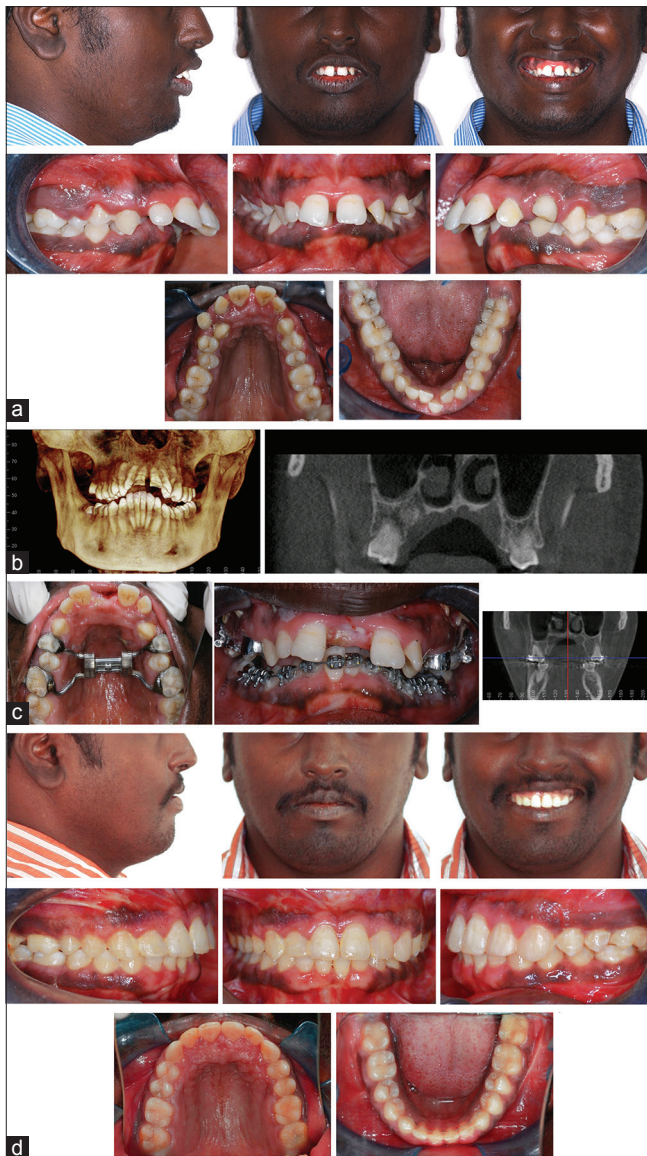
(a) 42-year-old male with retruded mandible, increased overjet and constricted maxilla and mandible. (b) Cone-beam computed tomography evaluation revealing constricted maxillary apical bone and compensated dentition. (c) Surgically assisted rapid maxillary expansion for widening the maxilla before mandibular advancement surgery. (d) Following mandibular advancement and post-surgical orthodontics.
